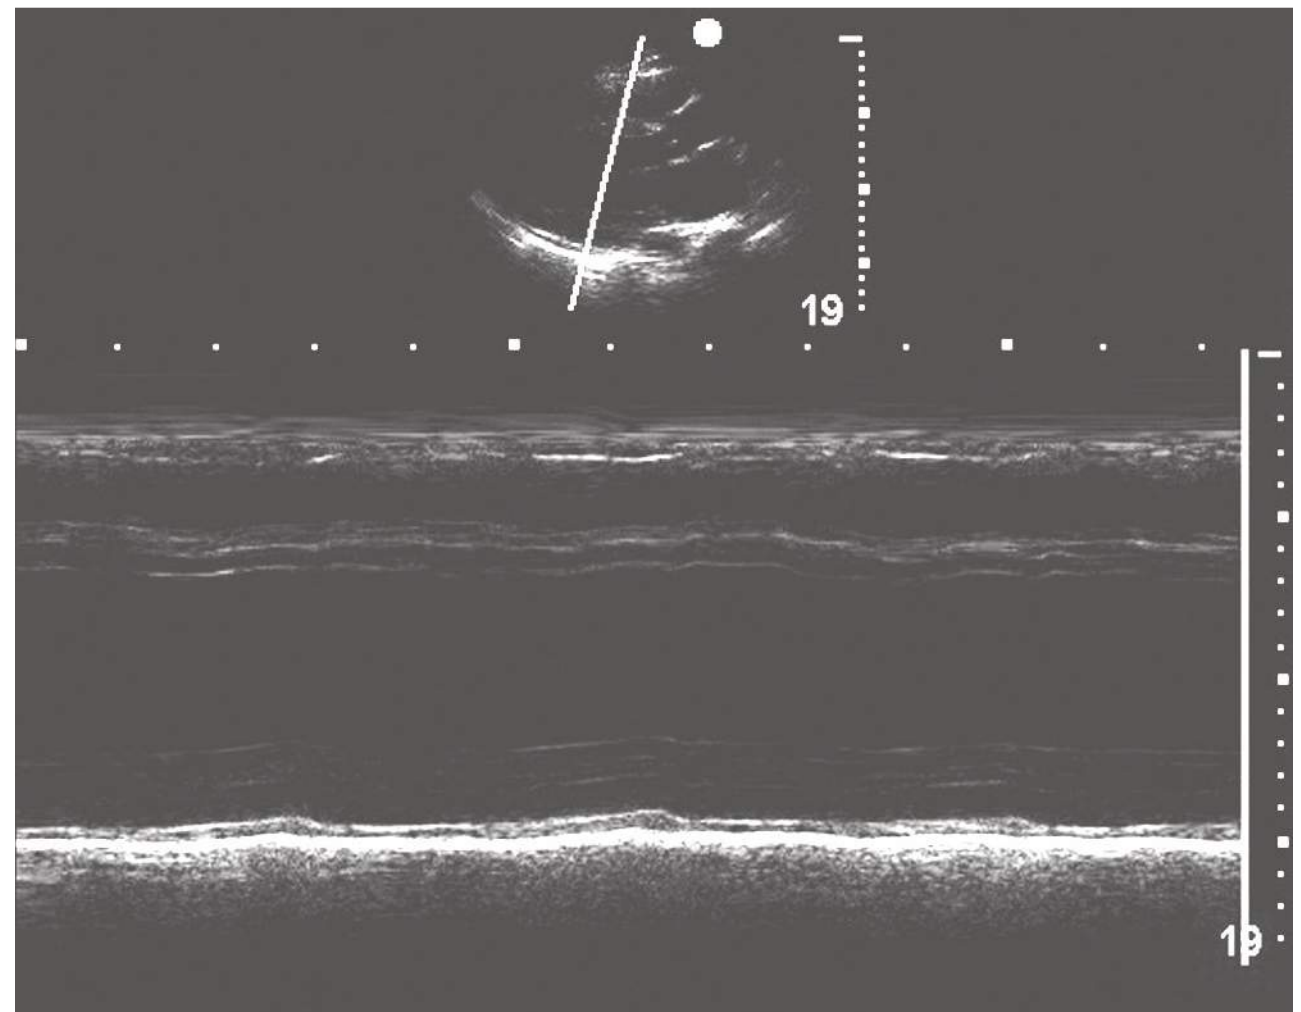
Parasternal long-axis M-mode view, poor ejection fraction. Parasternal long-axis M-mode view at the level of the papillary muscles with M-mode with marker bisecting the left ventricle. Note the severely reduced left ventricular (LV) systolic function as evidenced by the dilated LV, minimal change in LV diameter, and poor ventricular wall thickening during systole.
